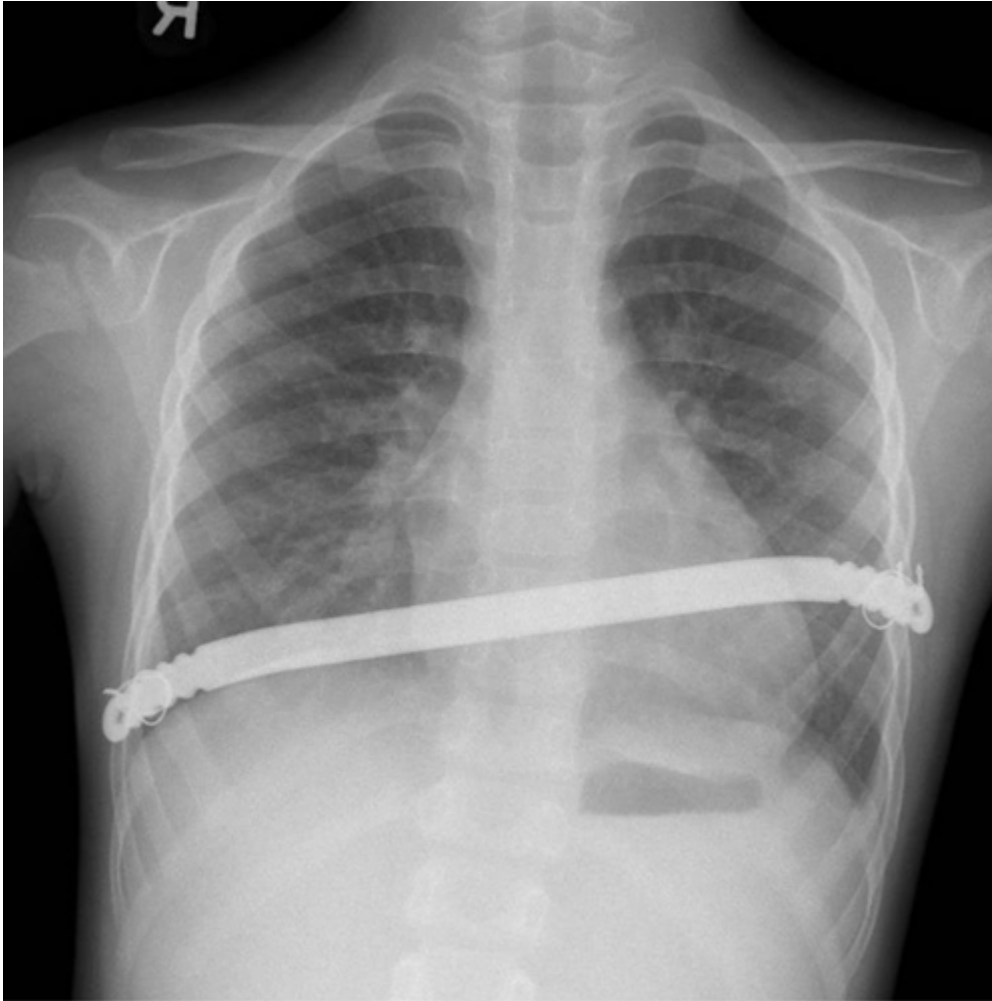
Chest X-ray revealed optimal position of Nuss bar with improved airway changes.
